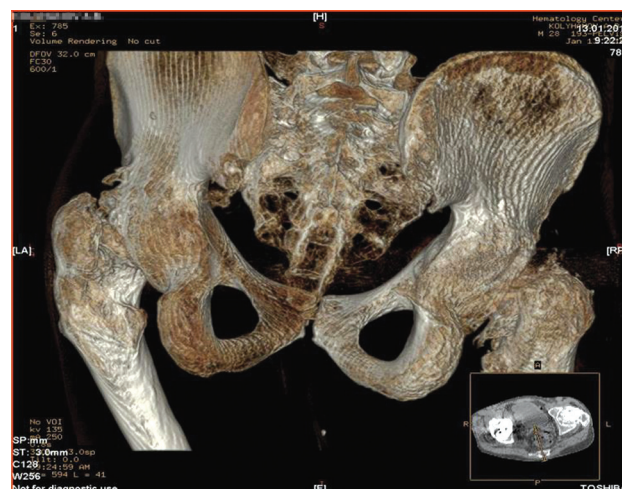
3D computed tomography of the pelvis and hip joints in Gaucher disease. Ankylosis of the left hip joint. Nearthrosis of the right hip joint
